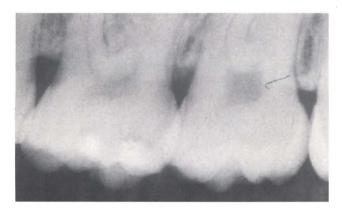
At year 6: Figure 5a. Radiographically, the lesions appear to be no deeper than at 6 months (see Figure 2a)
